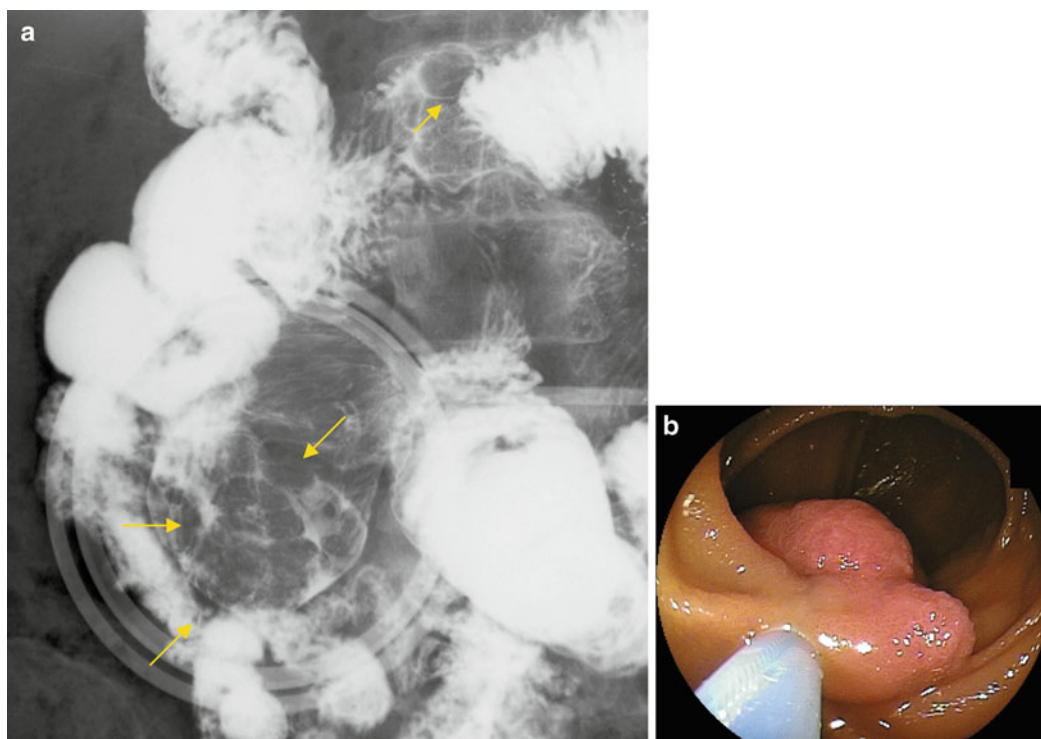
Endoscopic polypectomy. (a) A woman in her 1930s, diagnosed with PJS at 2 years old. She was examined in our hospital for intermittent abdominal pain. Per-oral contrast radiography of the small intestine showed
